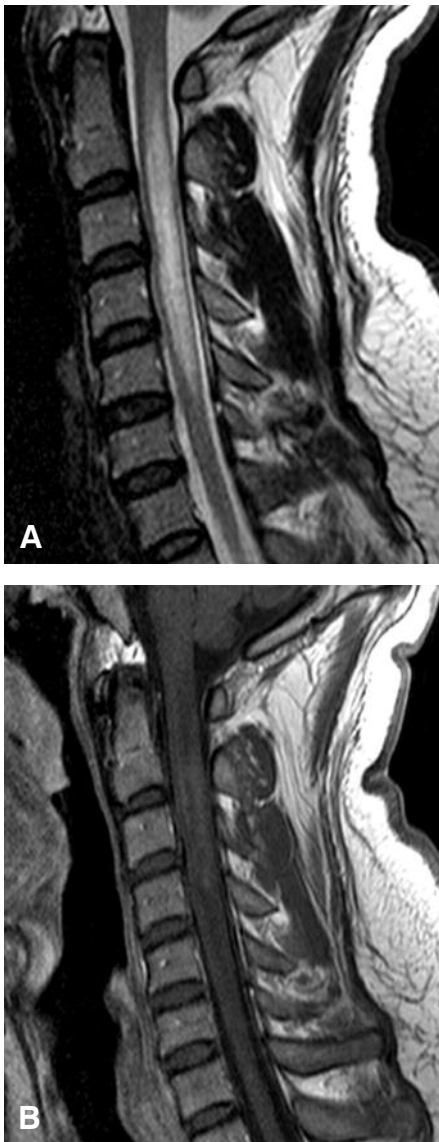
(A) Sagittal fluid-attenuated inversion recovery and (B) sagittal postcontrast MR images of the cervical spine obtained in November 2006 show the cervical cord expanded by a lesion that extends between C1 and C5.
